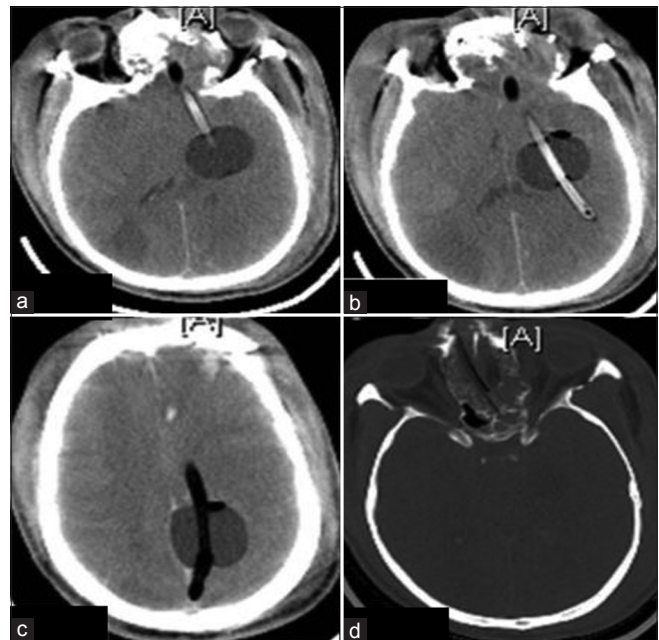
Axial sections on plain CT head showing malpositioned inflated Foley catheter in left temporoparietal region (a and b) There is evidence of previous attempted malpositioned Foley in the left occipital lobe (c) Bone window showing trajectory path from right nasal cavity to the brain via the cribriform plate (d)
